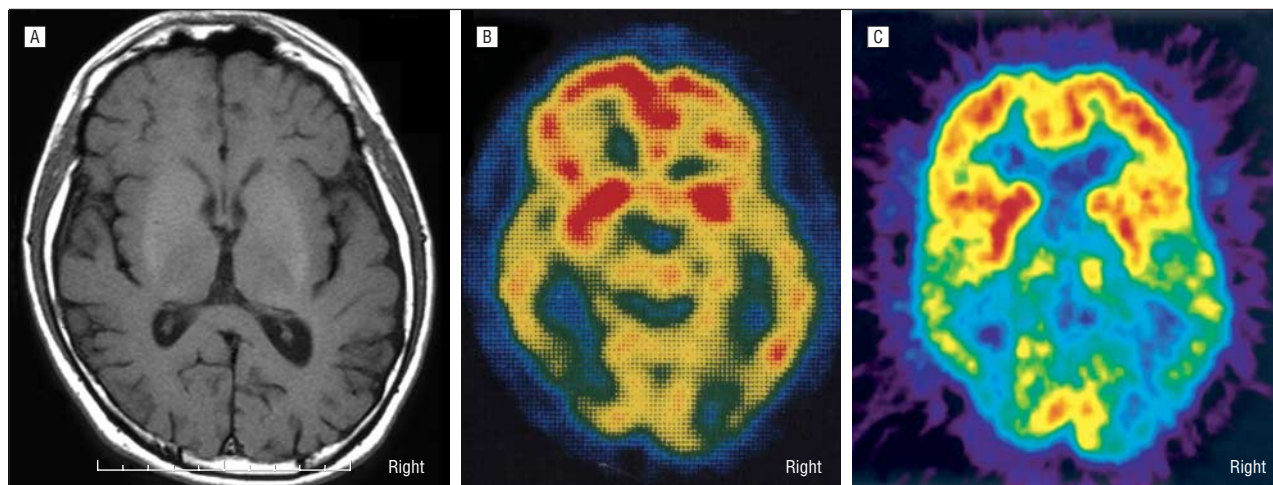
Neuroimaging study of the patient. A, Axial T1-weighted magnetic resonance imaging of the brain showed mild diffuse cortical atrophy by the standards for his age. Single-photon emission computed tomography (B) and positron emission tomography (C) showed hypoperfusion and hypometabolism in the bilateral occipital and temporal lobes.
